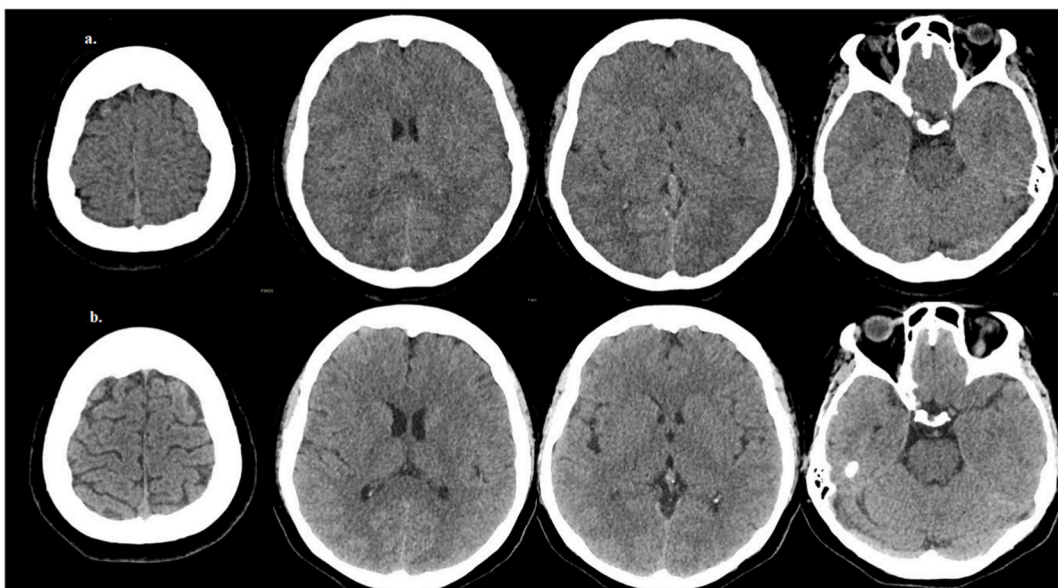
Initial non-enhanced cranial CT with generalized effacement of cerebral sulci and cerebellar folia, diminished ventricular spaces, and no evidence of herniation. Fig. 1b: Follow-up CT evidencing complete resolution of the cerebral edema.
